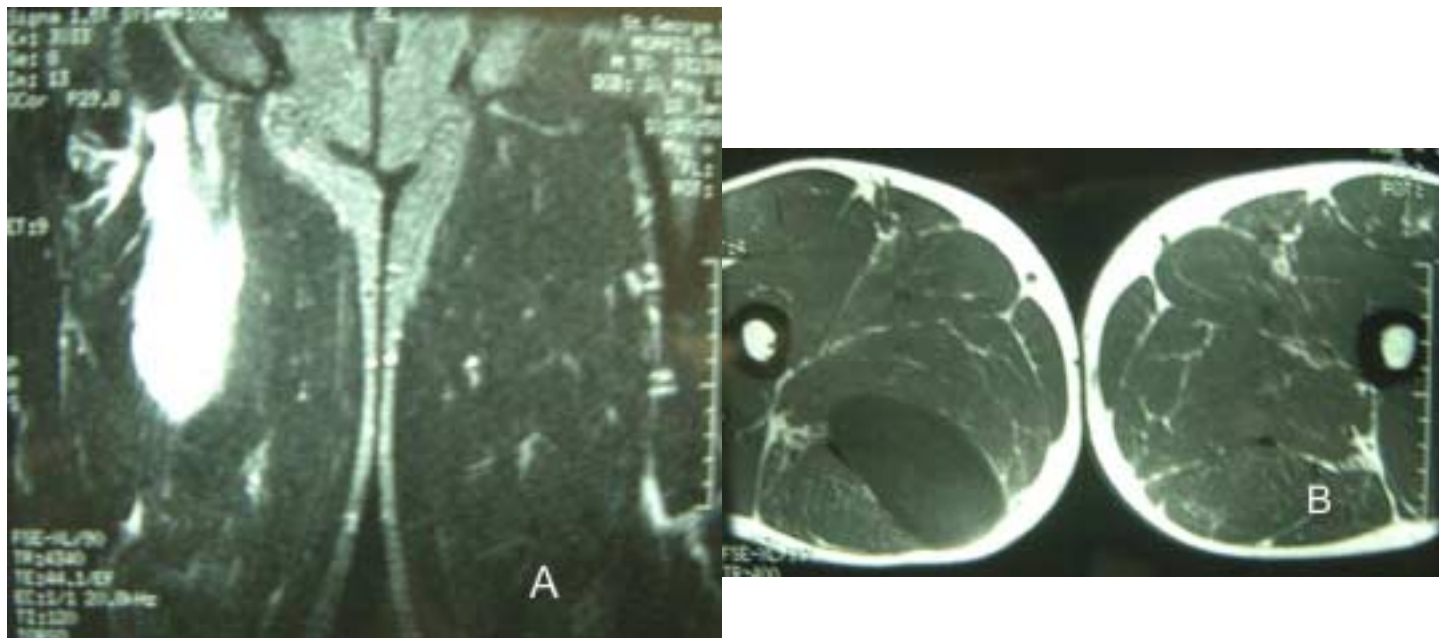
Coronal T2-weighted (A) and axial T1-weighted (B) MRI sections
